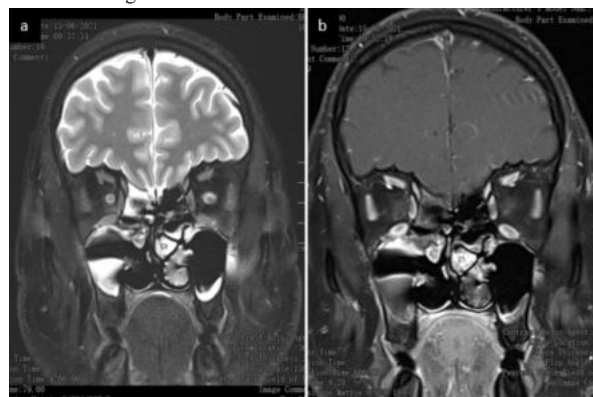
32 year old post covid patient of angioinvasive mucormycosis a) coronal T2 b) postcontrast T1 shows non enhancement of left inferior turbinate suggestive of Black Turbinate sign : an early indicator of ROCM on MRI
